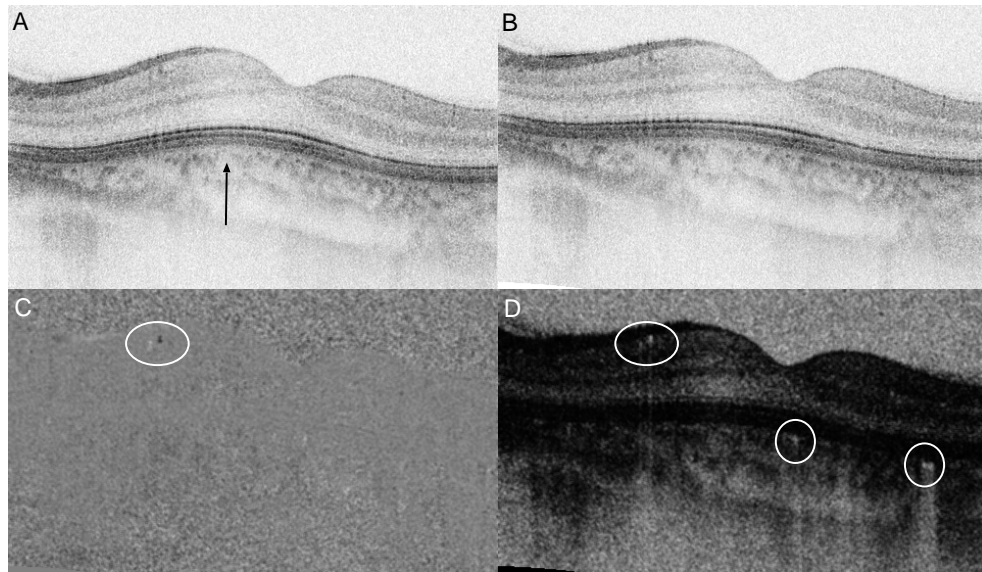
A sequence of OCT images and flow images of the human eye. Each image comprises 4000 axial scans and has a size of $5 \text{ mm} \times 1 \text{ mm}$ (lateral \times depth). The OCT images (A) without and (B) with the motion correction for adjacent axial scans are shown. The black arrow denotes the region in which axial image distortion has occurred. (C) Bi-directional flow and (D) the power of Doppler shift images show some vessels. Two retinal blood vessels appear in the bi-directional flow image (white circle). In the power of the Doppler shift image, the retinal vessels (upper white circle) and some choroidal vessels (two lower white circles) appear. Multimedia file is available on <http://www.opticsexpress.org/abstract.cfm?id=97672>
